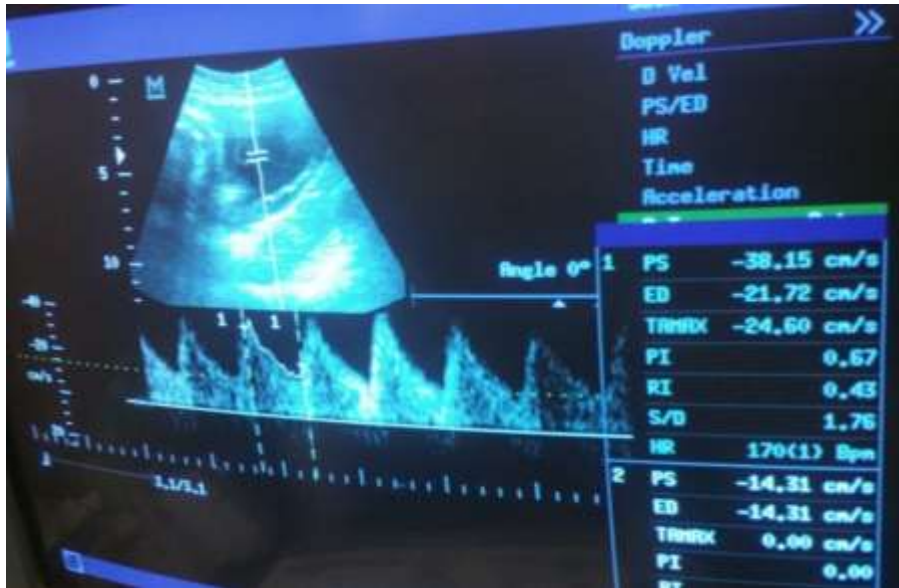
a) shows color Doppler umbilical artery waveform at 36 WKs
